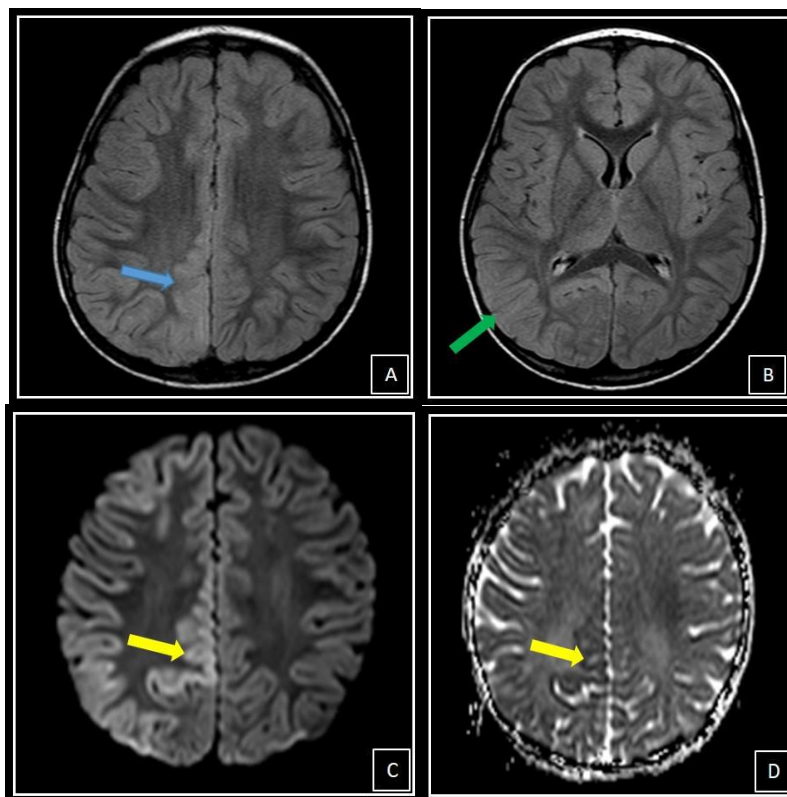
Cerebral Malaria A, B: FLAIR C: DWI D: ADC
